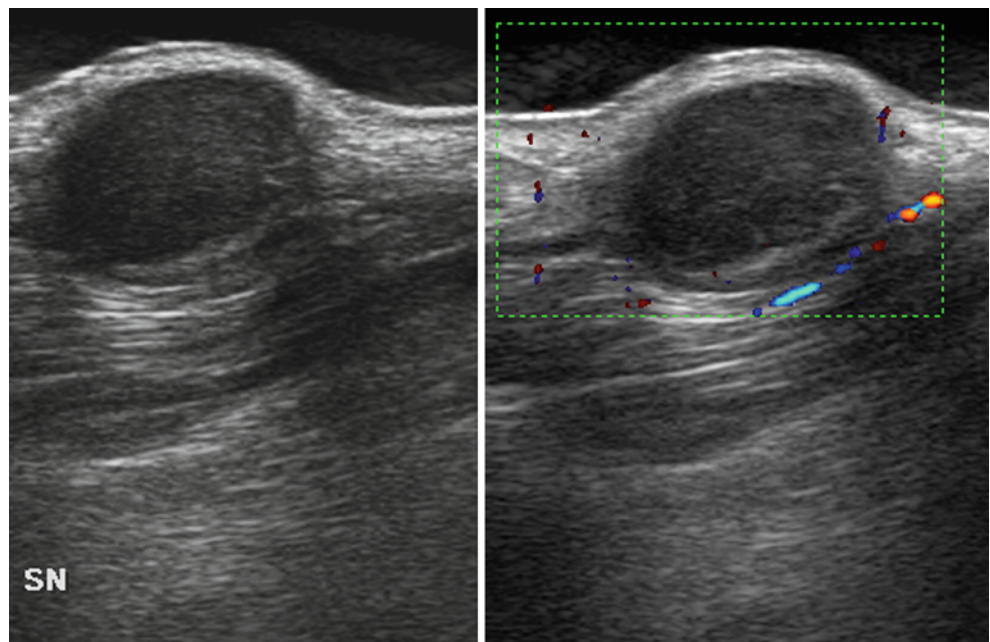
Recurring melanoma lesion of the neck. Use of a gel pad to adequately depict the hypoechoic, bulging nodule at sonography and power Doppler imaging
